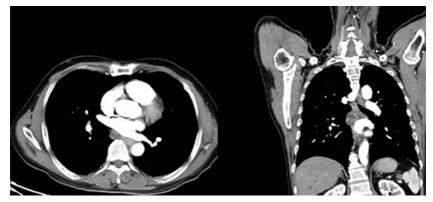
CT on 2/4/2015: lower and coronal
